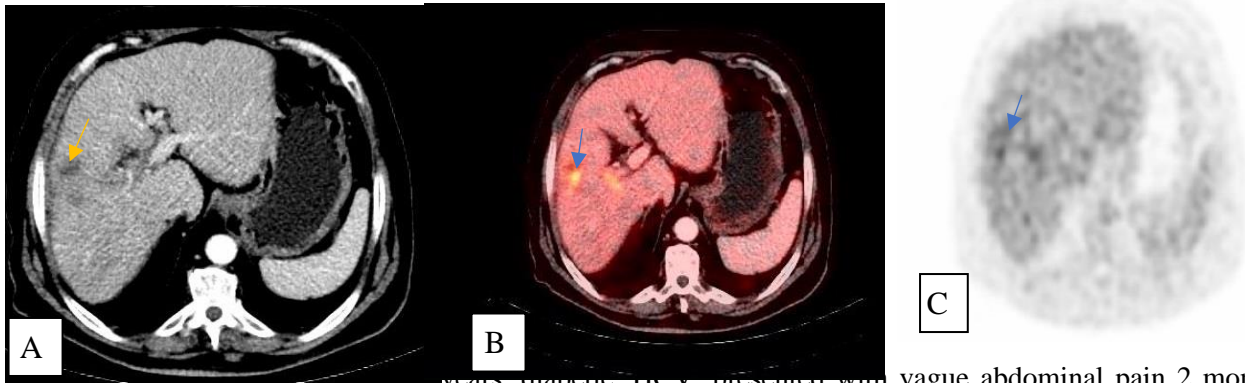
(A) Male patient aged 57 years, diabetic, HCV, presented with vague abdominal pain 2 months ago CT abdomen and pelvis with contrast revealed → cirrhotic liver with right hepatic lobe enhancing focal lesion with criteria of HCC biopsy was taken revealed moderately differentiated HCC, radifrequency ablation was done and follow up after 6 weeks. (A , B & C) Axial CT, PET/CT & PET images show peripherally metabolically active (blue arrow) right hepatic lobe hypo dense lesion (Yellow arrow) seen at segment V SUV max 6 denoting residual tumoral activity confirmed by Still elevated alfa fetoprotein (98 ng/ml).
